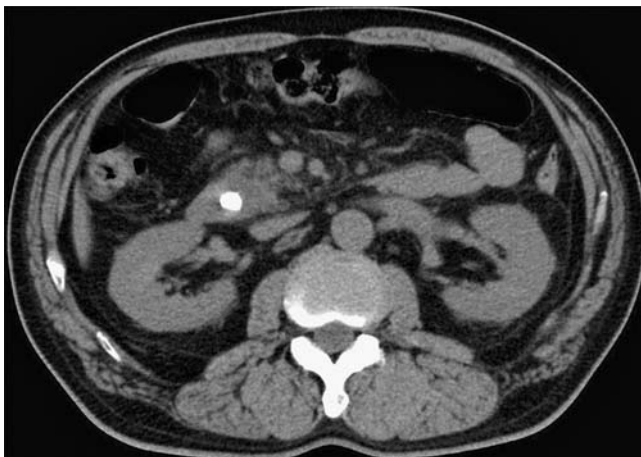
Abdominal plain computed tomography (CT) in a 70-year-old man with abdominal pain and high fever, showing a 10-mm calcified stone in the head of the pancreas.
